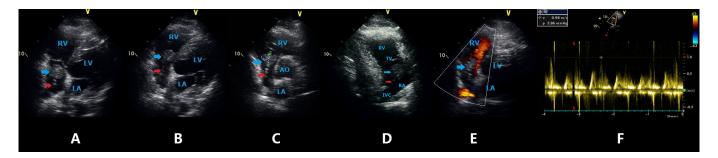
Echocardiography images. Parasternal four-chamber view (A, B) showing a substantial cloudy echo (blue arrow) that had a well-delineated boundary and smooth edges in the RA. Internal echo was uniform, and a long pedicle (red arrow) is connected to the mass. The mass showed a high mobility during the cardiac cycle. It was located in the RA in systole (A), and moved into the RV through the tricuspid valve in diastole (B), which caused the blood flow velocity across the tricuspid valve to increase to a maximum of 98 cm/s (F). CDFI showed no blood flow signal within the mass (E). In aortic short-axis section (C), the mass was measured 18 ×17 mm. The parasternal long axis view of the right ventricular inflow tract (D) showed one side of the pedicle (red arrows) connected to the mass (blue arrow); the other side was attached to the opening of the inferior vena cava in the RA.
